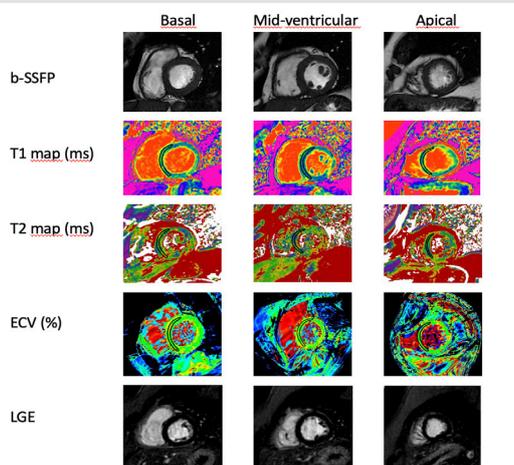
A 37-year-old male patient diagnosed with COVID-19 underwent cardiac MRI. The same slices of short axis view on basal, mid-ventricular, and apical segment (left to right) for balanced steady state free precession, T1 mapping, T2 mapping, ECV map and LGE images (up-to-down). T1, T2 and ECV mapping values showed increased values for entire ventricle (b-SSFP, balanced steady state free precession; ECV, extracellular volume; LGE, late gadolinium enhancement)
